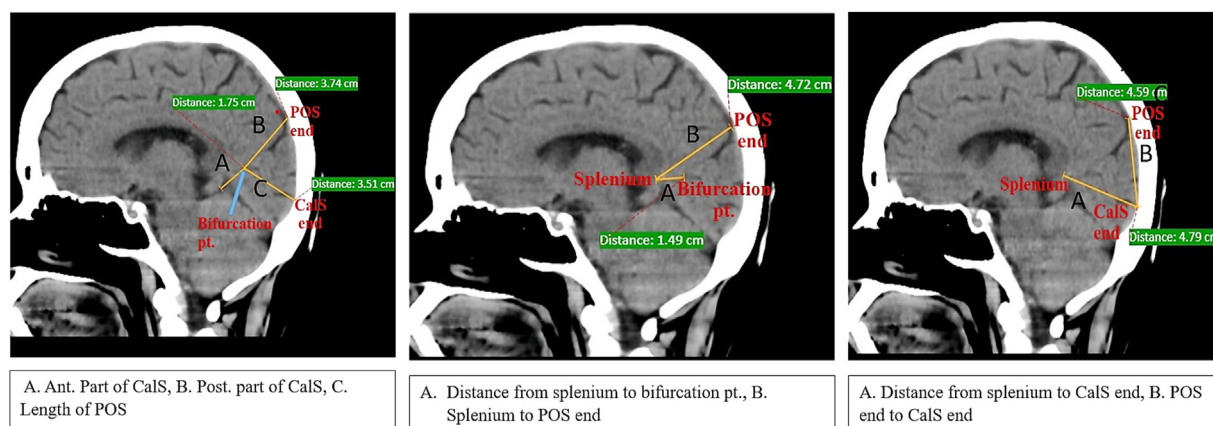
Measurements of the calcarine and parieto-occipital sulci in CT scans.
